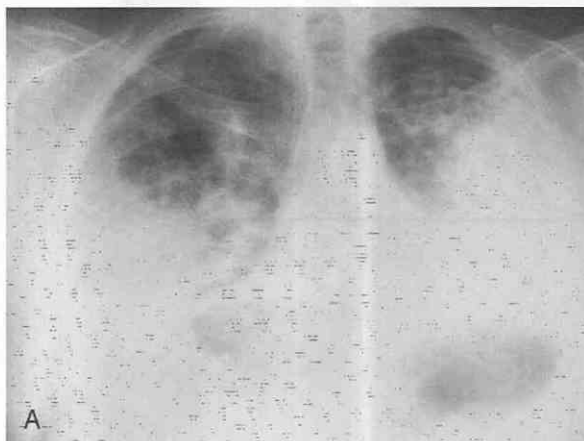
Bronchioloalveolar cell carcinoma appearing as homogeneous opacities mimicking pneumonia. A, Posteroanterior chest radiograph shows diffuse, bilateral, homogeneous pulmonary opacities. Surgical clips are present in the medial aspect of the left hemithorax because of prior partial pulmonary resection. B, CT confirms the diffuse bilateral pulmonary consolidation and reveals a small left pleural effusion.
